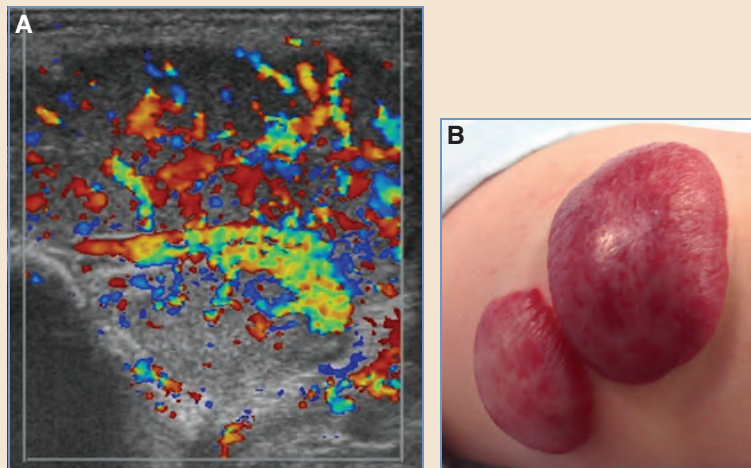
Typical ultrasonography of infantile hemangioma. A, Proliferative phase of parotid infantile hemangioma. The solid echogenic tumor parenchyma is hypervascular with a high vessel density. The solid parenchymal component of the infantile hemangioma distinguishes it from an AVM. B, Early involutory phase of two cutaneous infantile hemangiomas.
